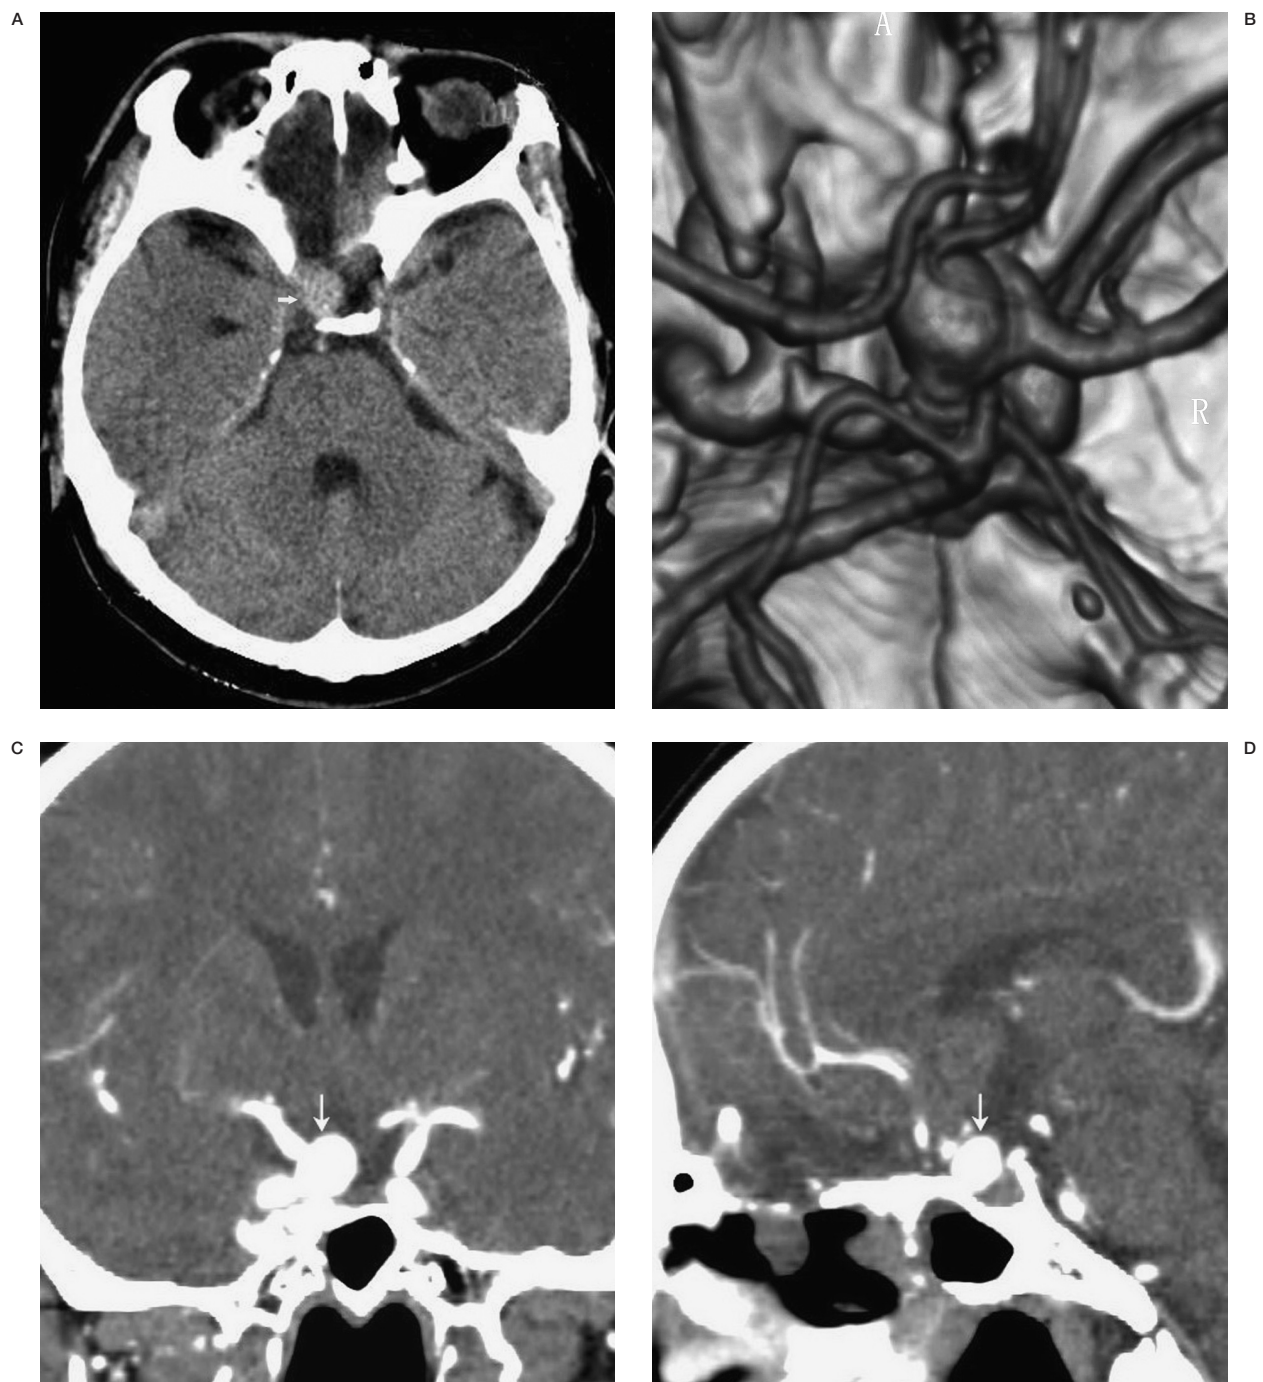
A) a nonenhanced CT image reveals a mass lesion (arrow) in the right suprasellar cistern. B) Volume-rendering techniques (VRT) CTA reveals a large saccular aneurysm originating from the PcoA. C,D) Coronal and sagittal reconstructions of enhanced CT images showed the pituitary stalk compression by the the PcoA aneurysm (arrow).
